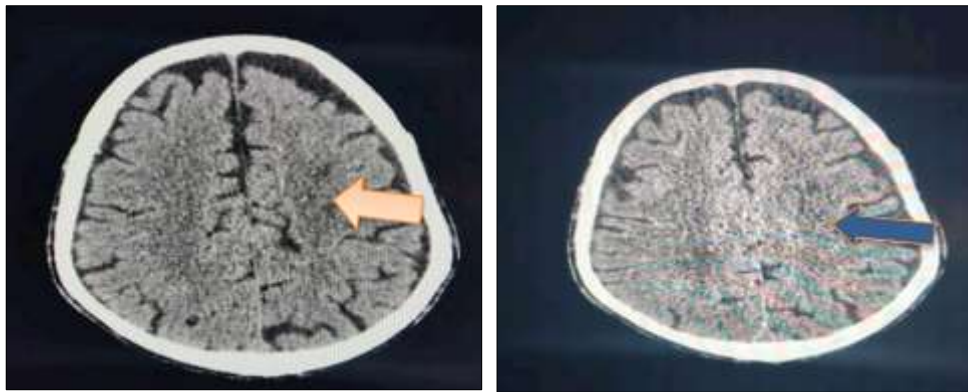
CT Scan Showing Acute Left Cortical Infarct (Shown with orange and blue arrow)
